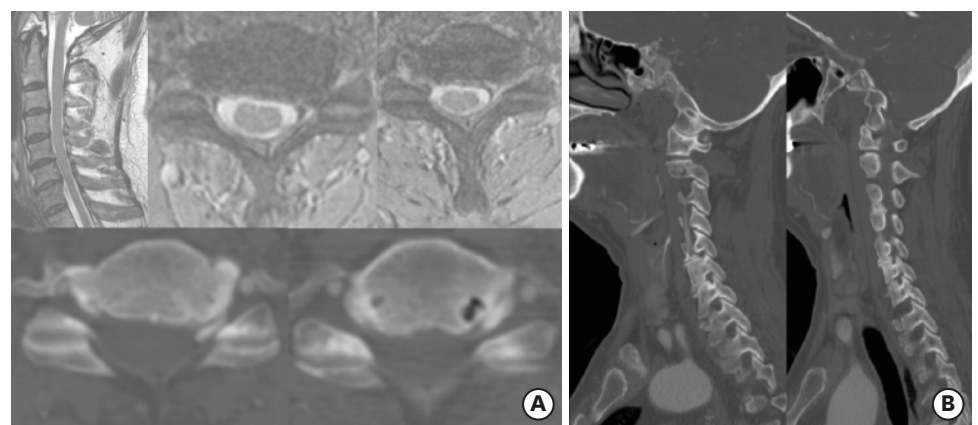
(A) 70-year-old male patient complained of severe left-side arm pain (numeric rating scale: 9) despite 6 months of medication treatment. Preoperative magnetic resonance imaging and CT scan show left parallel-shaped foraminal stenosis at the C5-6 and C6-7 levels. (B) Post-operative 1-year CT scan shows correct screw position and extensive decompression on the same level consistent with the successful surgical outcome. CT: computed tomography.
